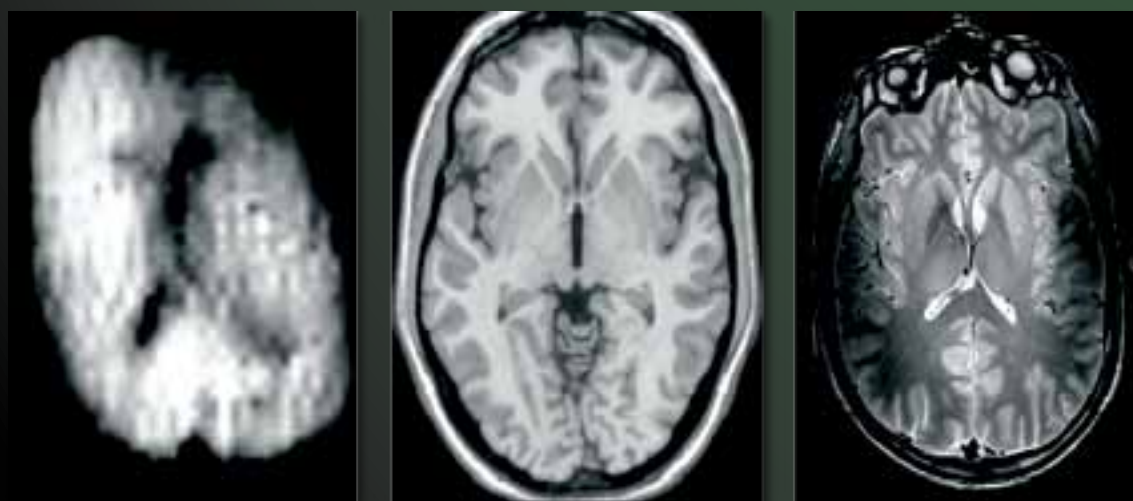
Improvement of MR images of brain structure in the last 30 years
